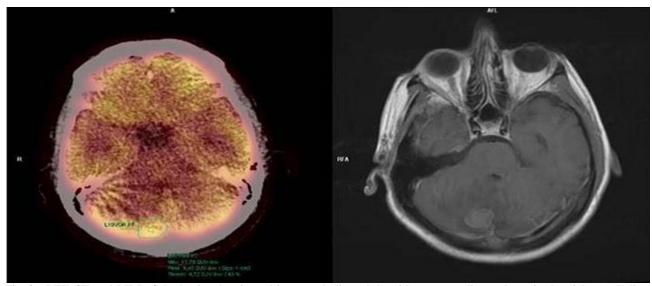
PET-CT and MRI of the brain, showing a hipermetabolic nodule with sourrounding oedema in the right cerebellar hemisphere.
